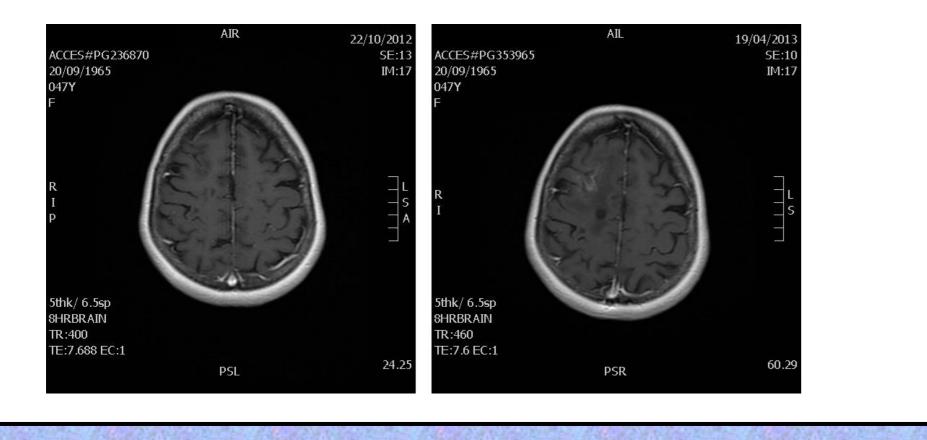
Patient F.C. MRI T1-weighted; control MRI at 1 month showed slight ring contrast enhancement.
